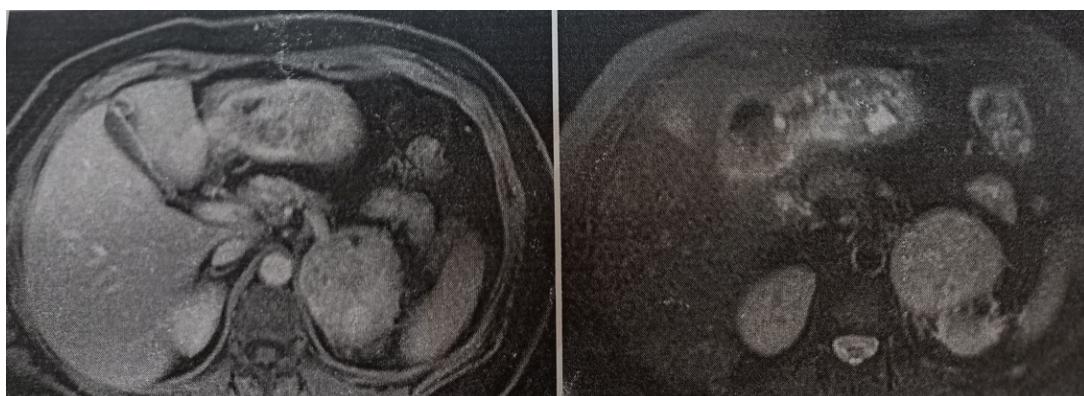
Magnetic resonance imaging showing a large mass in the left adrenal gland with high signal intensity on T2-weighted images, low signal intensity on T1-weighted images, and inhomogeneous contrast enhancement.
